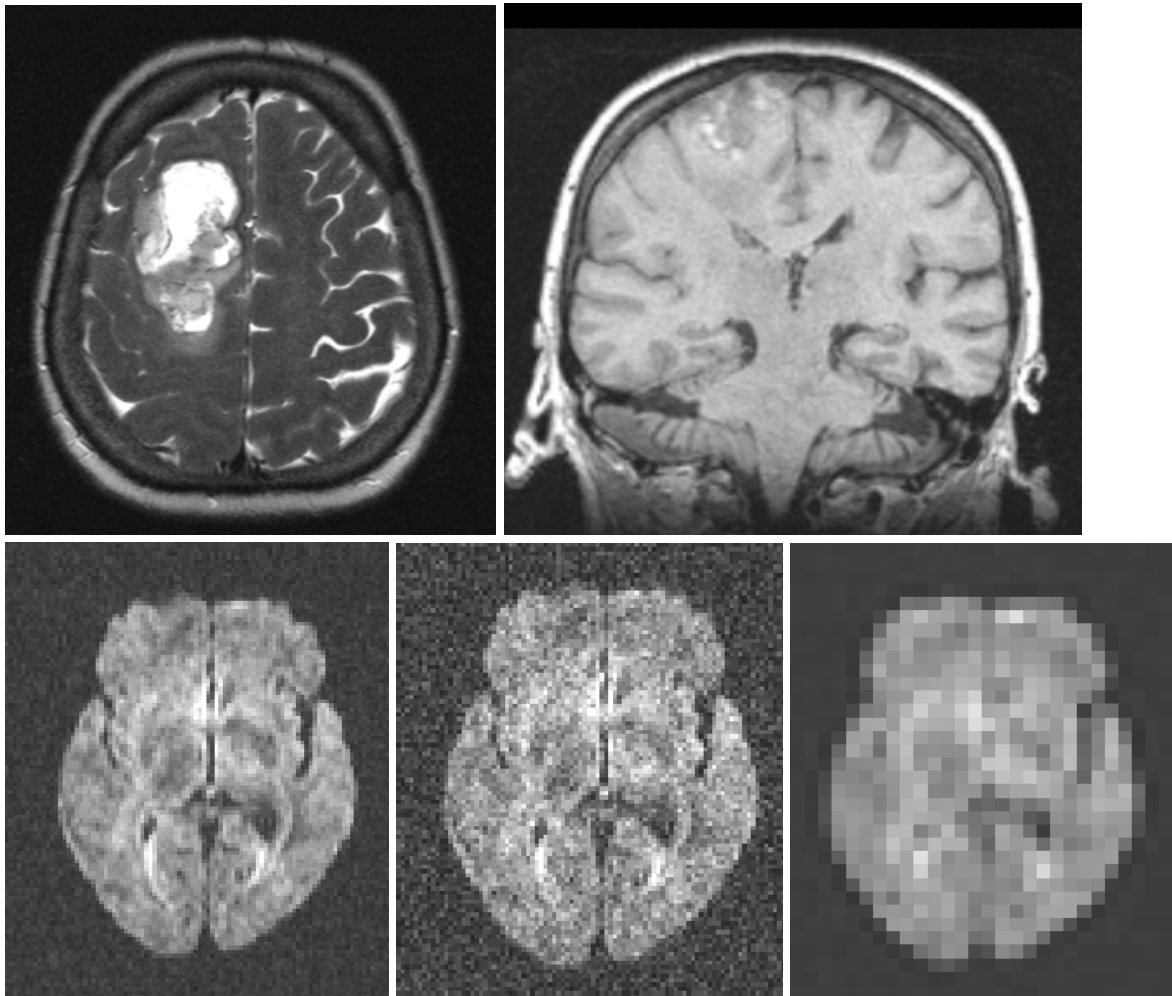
MRI data of glioma patient; top left: axial T2 weighted image, top right: coronal T1 weighted image; bottom left: original DTI data (first of six gradient directions, $b=1000$); bottom center: same as before but additive complex Gaussian noise ($\sigma = 20$, compare to Figs. 3 and 4 bottom right); bottom right: same as bottom left but downsampled to an isotropic resolution of $6 \times 6 \times 6 \text{ mm}^3$ (compare to Figs. 3 and 4 middle row, right image).
